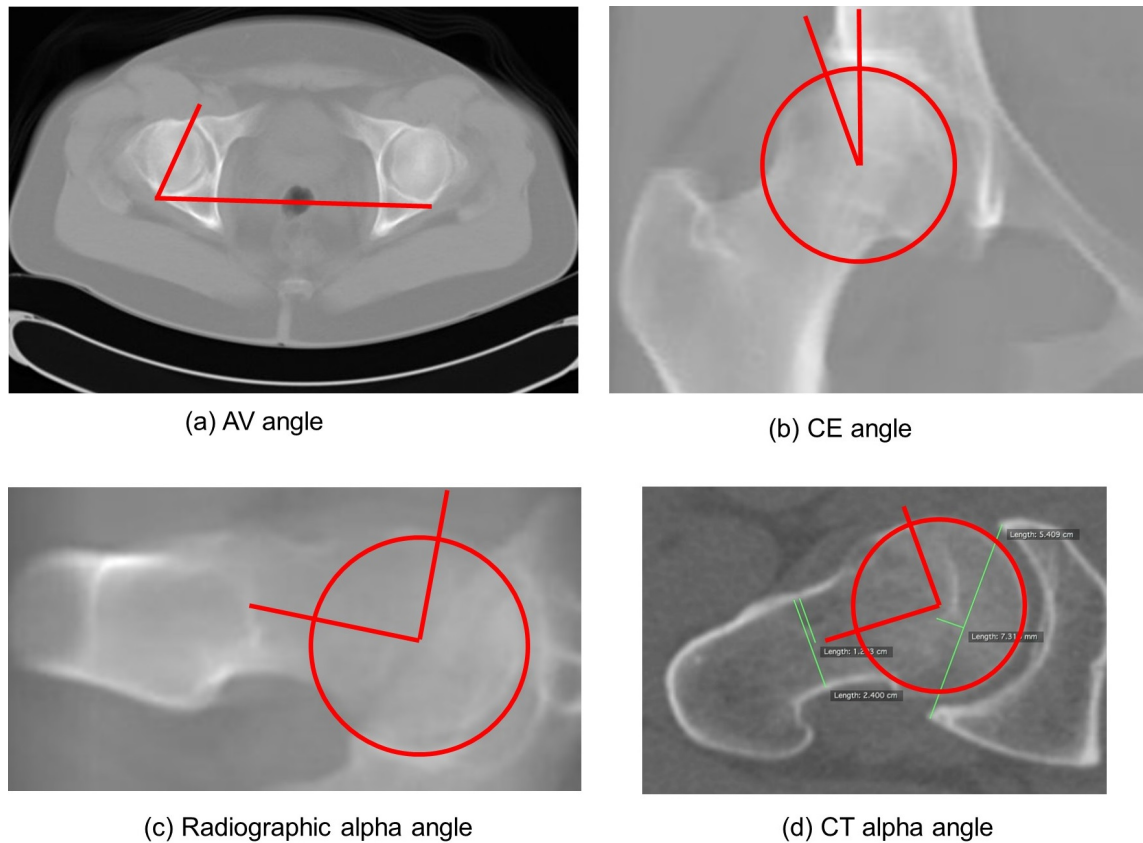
Examples of 2D measurements performed on radiographs in OsiriX:
